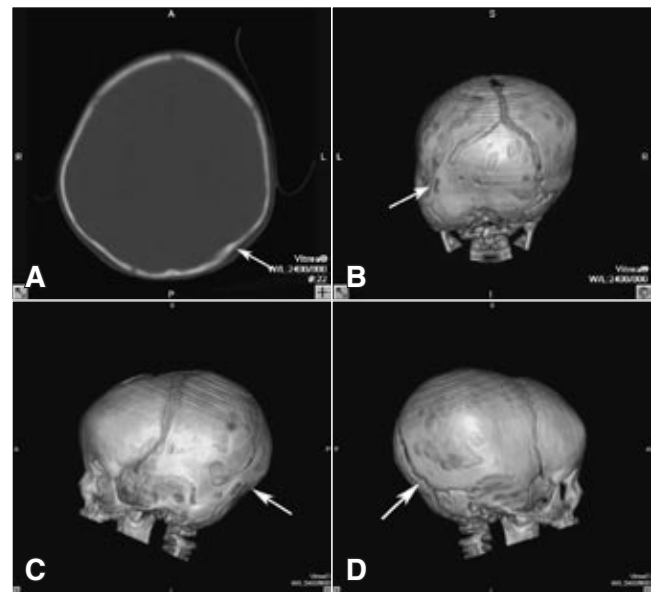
Patient with left unilateral lambdoid synostosis: 2D-CT axial slice depicts a closure of the left lambdoid suture (arrow) (A); 3D-CT images show in rear (B) and left lateral (C) (arrows) views the left lambdoid suture premature closure. Right lateral (D) view shows the normal lambdoid suture (arrow).
